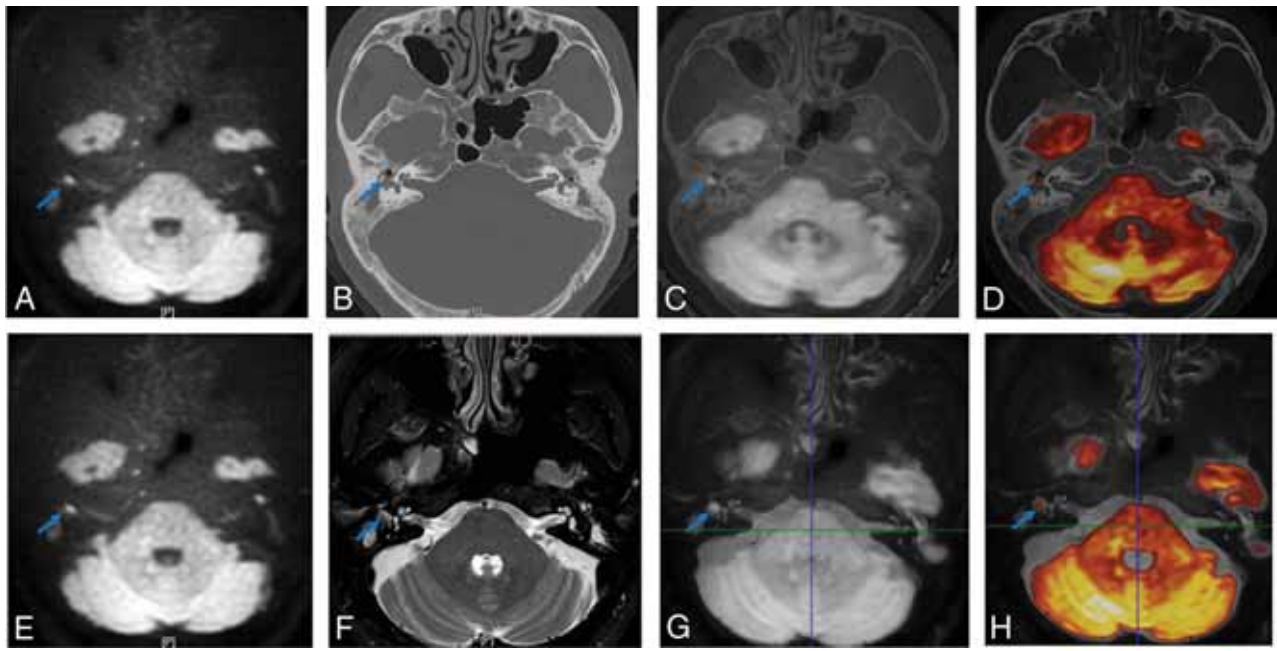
TSE-DWI images (A and E) were fused with HRCT (B) and T2WI fat-suppression images (F), respectively, to generate CT-DWI (C) and T2WI-DWI (G) fusion images, converting the colors to increase the visibility of the lesion (blue arrow) (D and H).
